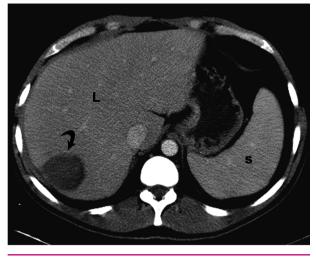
Patient #1 four months following embolization. Abdominal CT demonstrates near complete resolution of the subcapsular hematoma of the liver, as well as reduction in the size of the segment 7 hepatic lesion (curved arrow). L=liver; S=spleen
